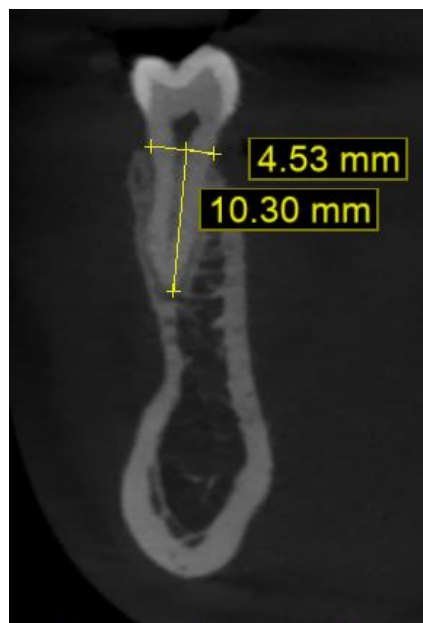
Measurement of cbct image
